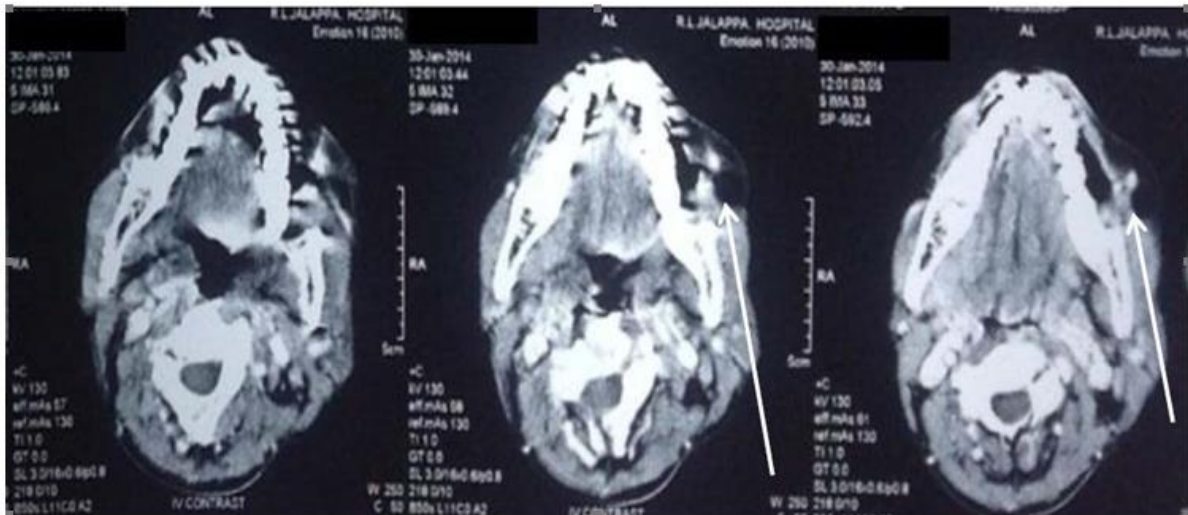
Baseline CT scan of patient with carcinoma buccal mucosa before initiation of treatment, arrow pointing towards tumor site.
